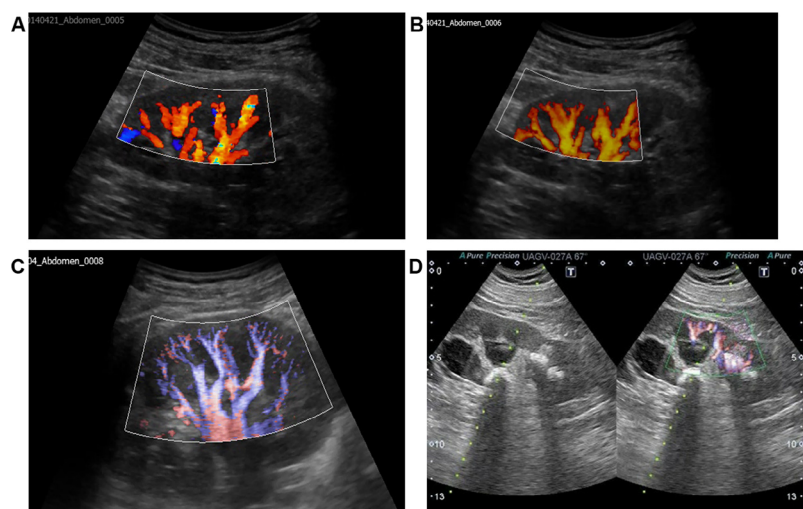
Doppler ultrasound images in same ultrasound system. (A) Color Doppler mode; (B) power Doppler mode; (C) wideband Doppler mode; (D) twin-view image of B-mode and wideband Doppler modes during puncture. Percutaneous puncture was performed in real time to detect and avoid renal blood vessels. (Color version available online.)
